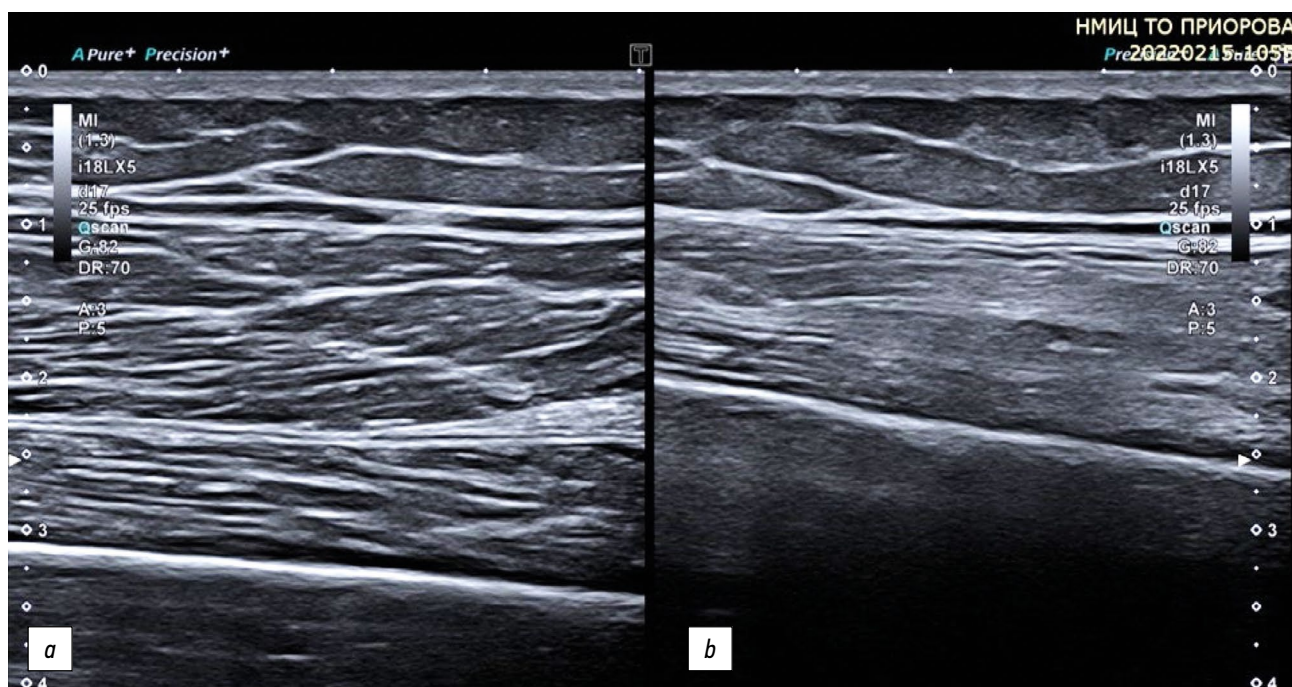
Denervation changes in the quadriceps femoris muscle, longitudinal sonogram. (a) unchanged muscle, (b) denervated muscle: the muscle volume is reduced in volumewith increased echogenicity, and no differentiation of fibers.
